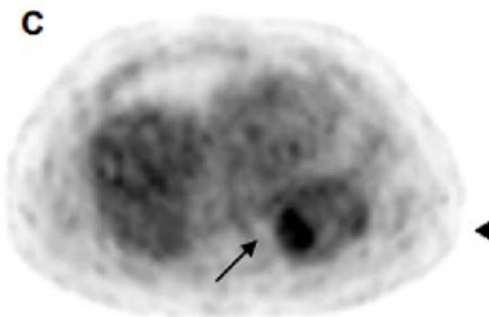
A: macro (0.5x) image of carcinoma (white arrow)in fibrotic lower left lobe at autopsy. B and C: 18F-FDG PET scan of malignancy, black arrows points to an area of intense FDG accumulation of 47 x 41 x 24 mm and a SUV max of 4.85. Comparison with serial HRCT scans demonstrated consolidation in the corresponding area.
